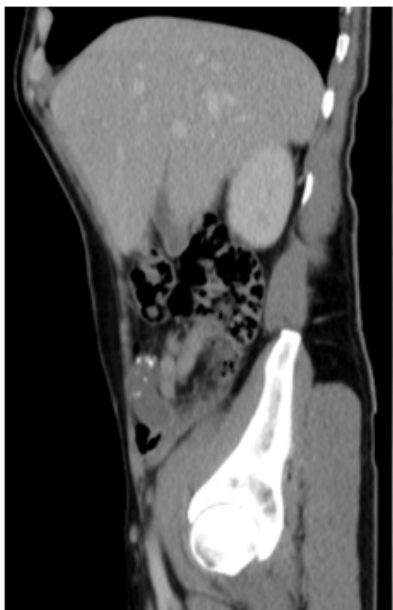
Sagittal CT scan image showing a dilated appendix measuring up to 2.1 cm with mild inflammatory periappendiceal fat stranding and calcification.
